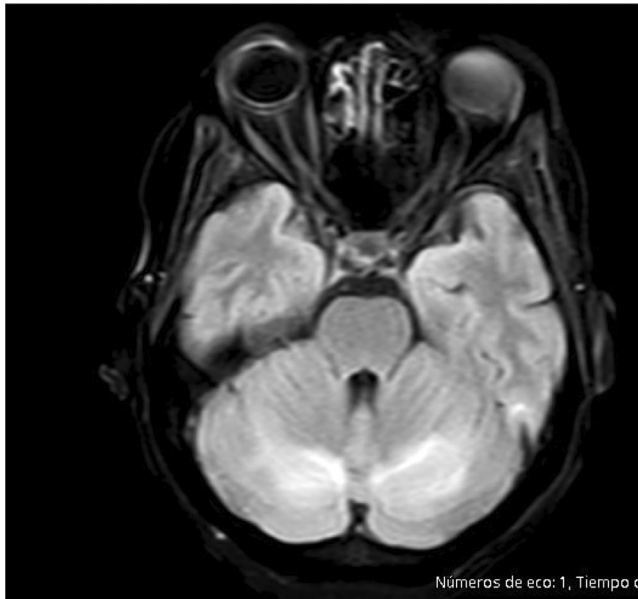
Hypersignal in both cerebellar hemispheres, FLAIR.
